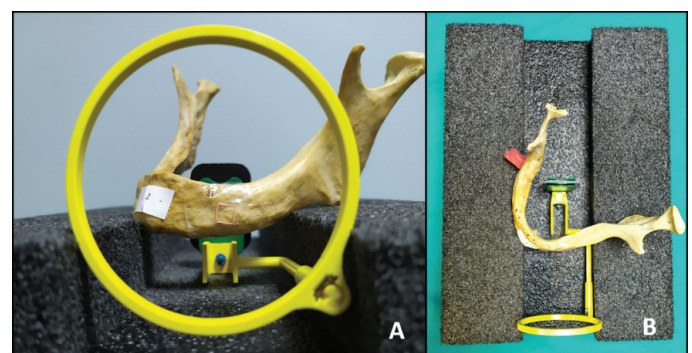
A, Positioning of the mandible and apparatus for taking periapical radiographs with the parallel technique. B, mandible was placed on a hard and constant floor for stabilization.
